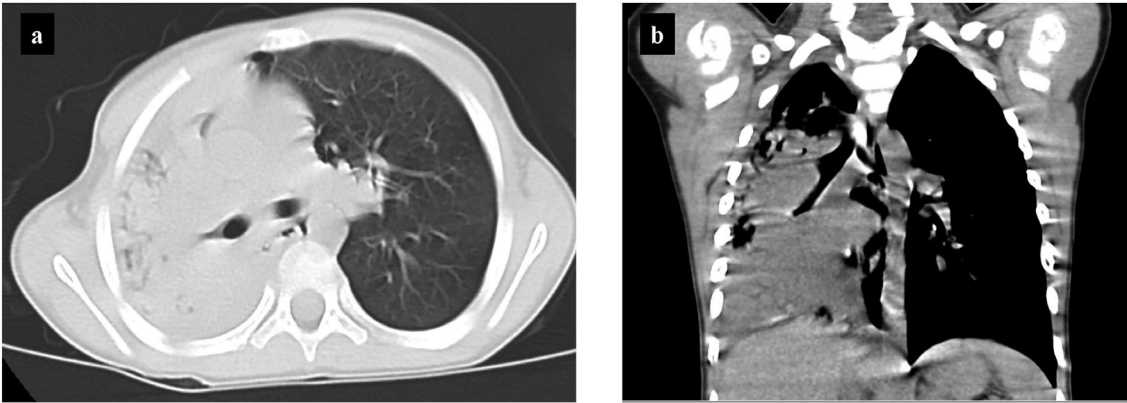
Chest CT images at hospitalization. Chest CT (a) an axial image and (b) a coronal section image at hospitalization showed atelectasis of the right middle and lower lung lobes. CT, computed tomography.
